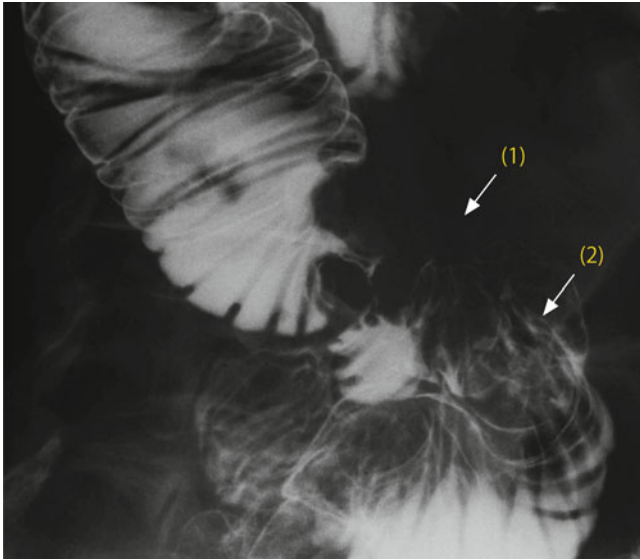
Radiography revealed a smooth filling defect (*arrow 1*) and a faint barium fleck, together with convergence of the wall on the distal side (*arrow 2*)
